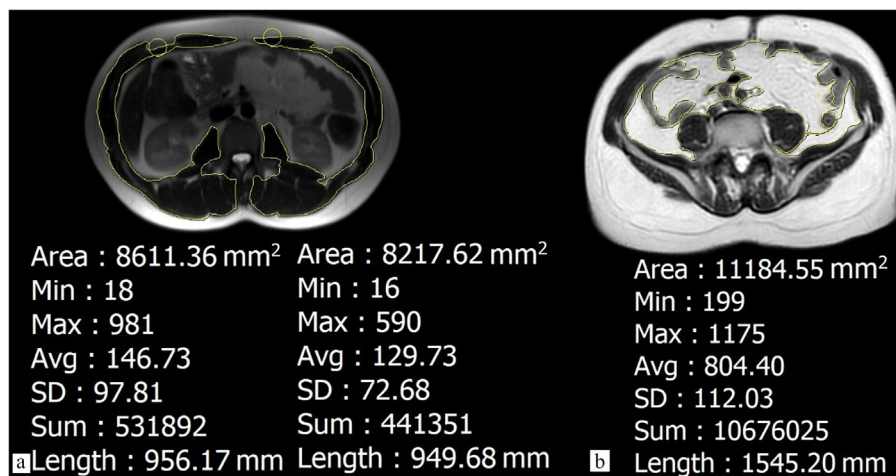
Axial T2 weighted MRI images. (a) Total skeletal muscle area calculated by free manual tracing method at the third lumbar vertebra. (b) Visceral adipose tissue area calculated by free manual tracing method at the level of umbilicus.
